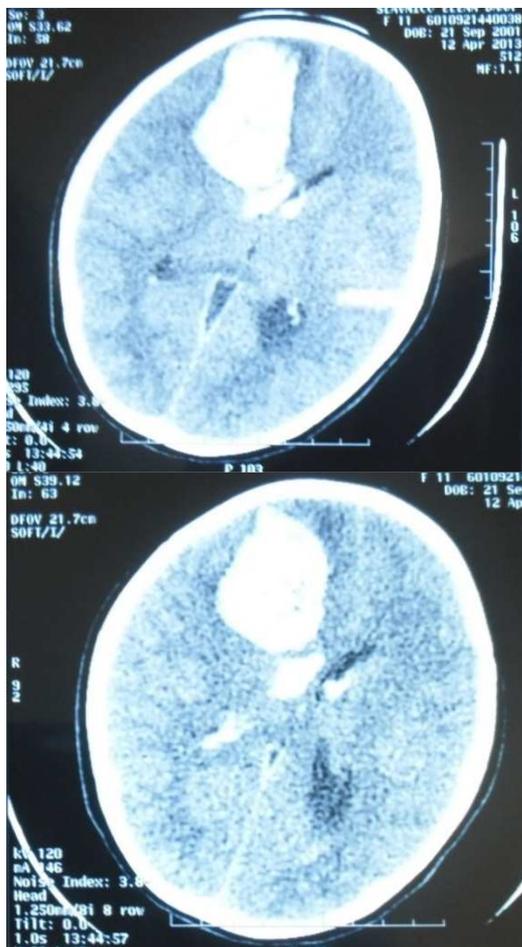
CT scan at admission, showing a large right frontal hematoma and intraventricular hemorrhage, with significant midline shifting
